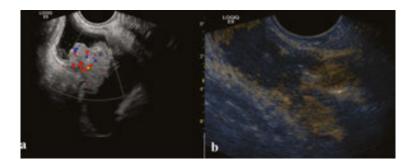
Rectal tumor investigated with Doppler ultrasound (a) and with CEUS (b). The contrast examination is performed after radiotherapy. Note the partial response to the treatment.
